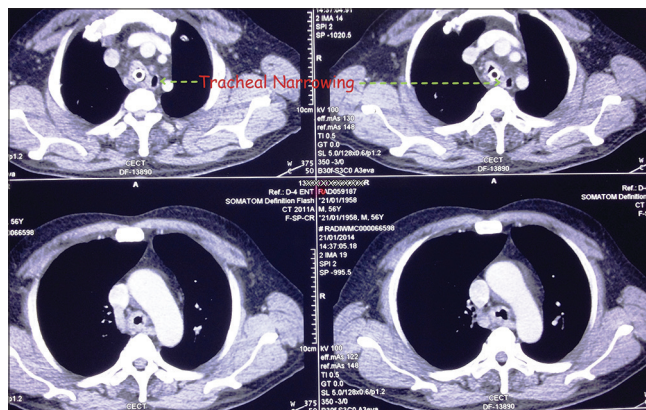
Computed tomography scan shows trachea narrowing
